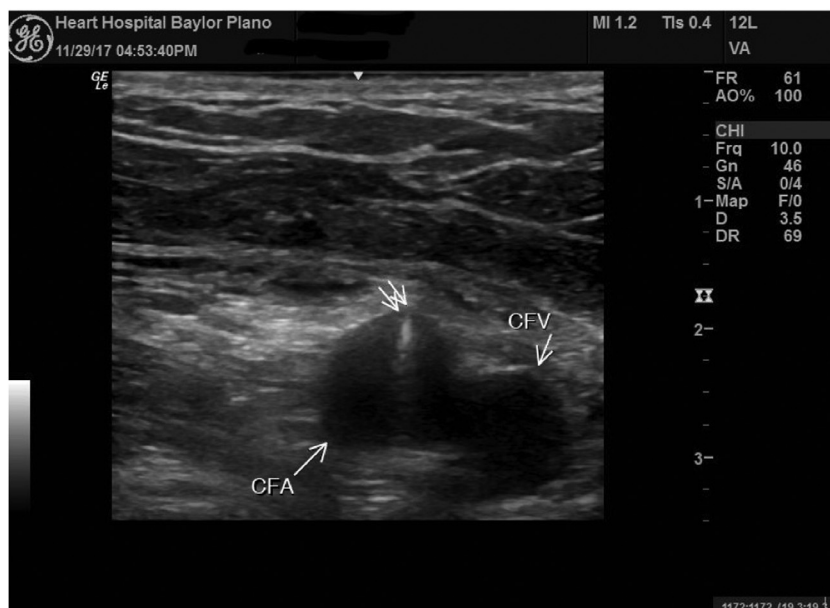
Ultrasound-guided access.
